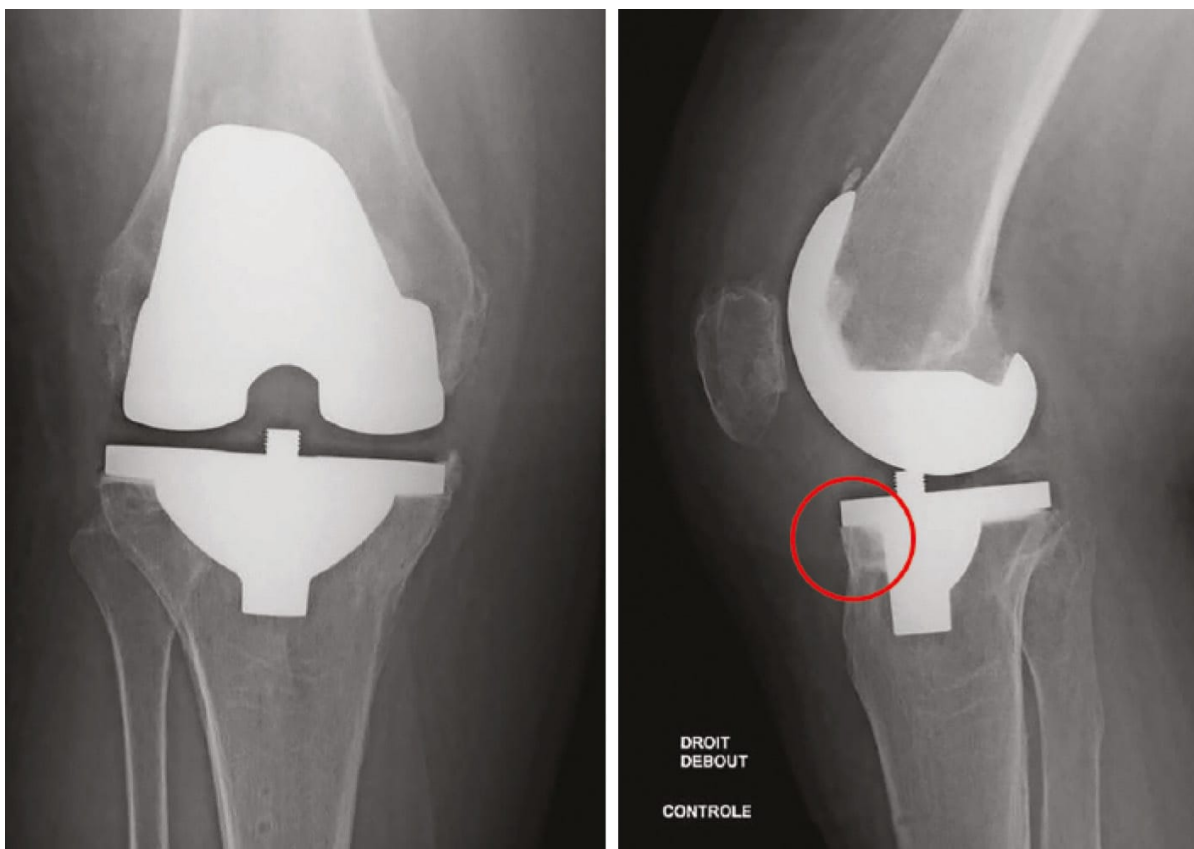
Radiographic assessment of the tibial window.
